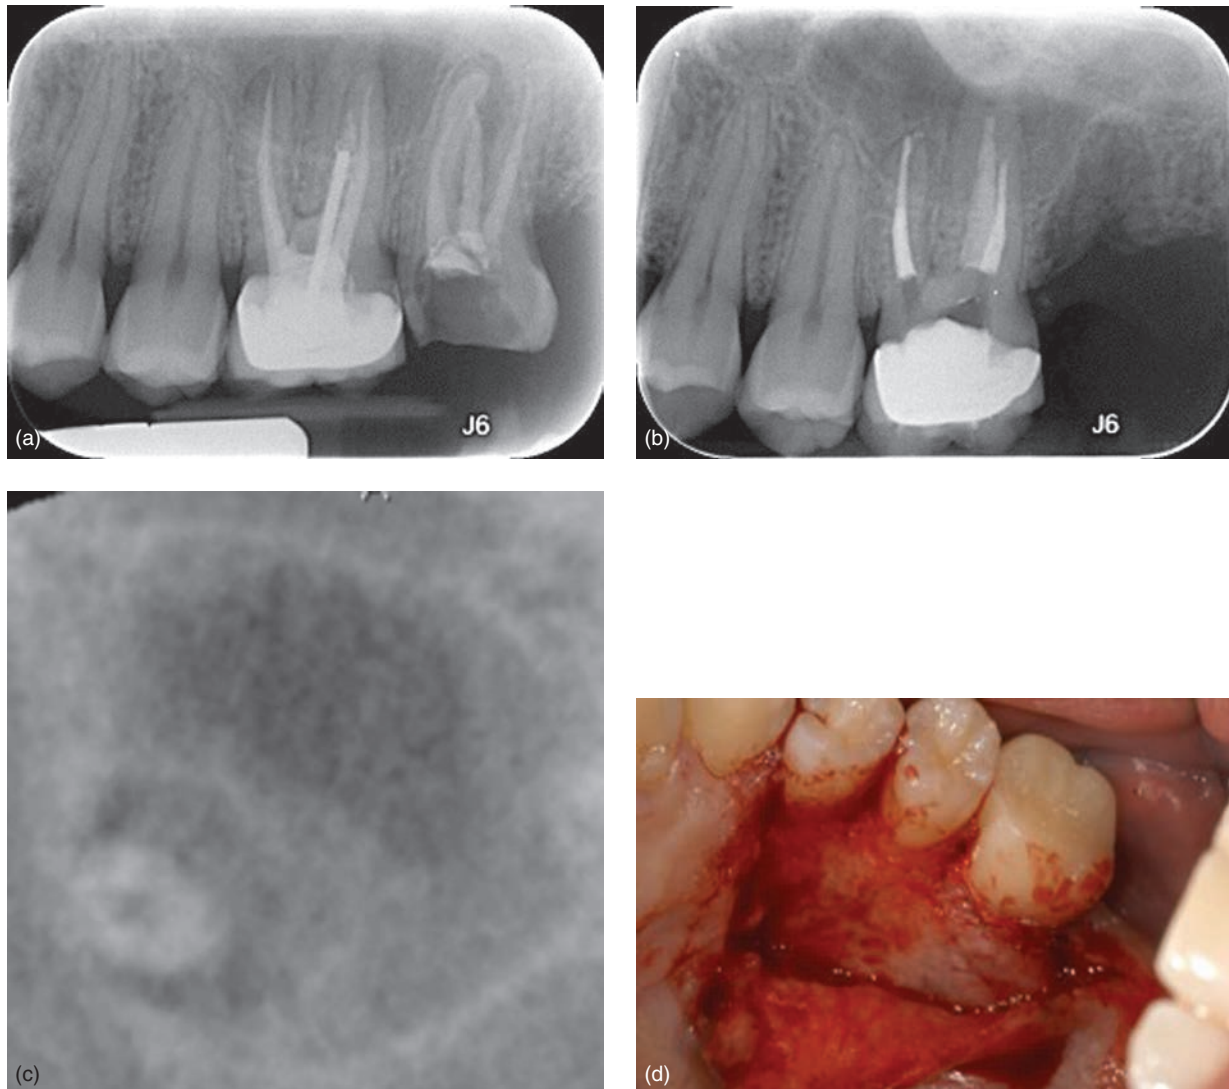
History of palatal root postperforation maxillary left first molar; sealed internally with MTA and treatment planned for palatal surgery to remove the apical part of the root with lesion. (a) Preop conventional retreatment. (b) Postop conventional retreatment with MTA orthograde filling in the palatal root. Note that the maxillary left second molar was extracted due to non-restorability. (c) Slice from CBCT showing the palatal root near the palatal bone and not in the maxillary sinus. (d) Surgical site exposed.
